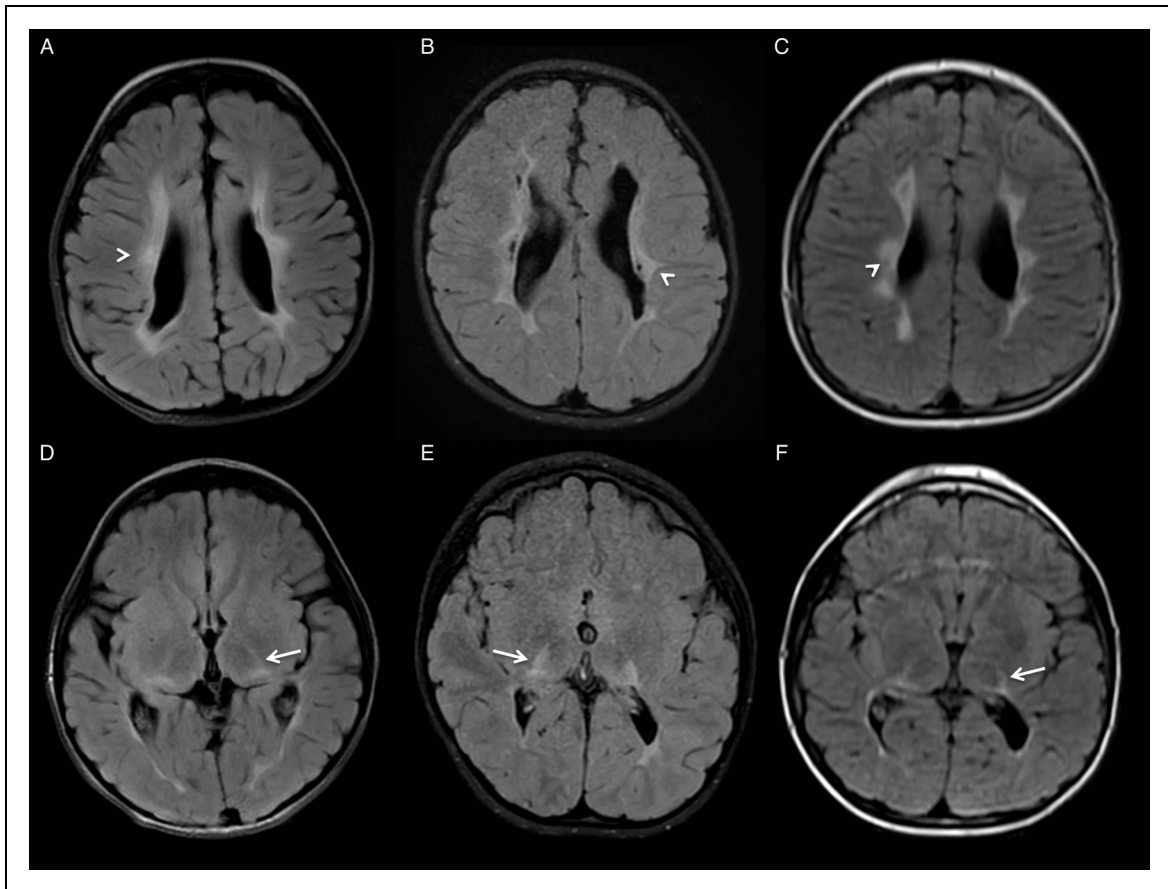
Cases of periventricular leukomalacia with the thalamus L-sign on various MRI scanners. (A, D) A 6-year-old girl with a history of prematurity (27 weeks) on a 3-T MRI; (B, E) a 6-year-old boy with a history of prematurity (36 weeks) on a 1.5-T MRI; (C, F) and an 8-year-old boy with a history of prematurity (28 weeks) on a 1.2-T open MRI system. Axial fluid-attenuated inversion recovery (FLAIR) images reveal the thalamus L-sign, a hyperintense signal in the posterolateral margin of thalami (arrows). In addition, all images display periventricular high-signal areas, wavy lateral ventricle borders, and white matter volume loss, which are all characteristics of periventricular leukomalacia (arrowheads).
